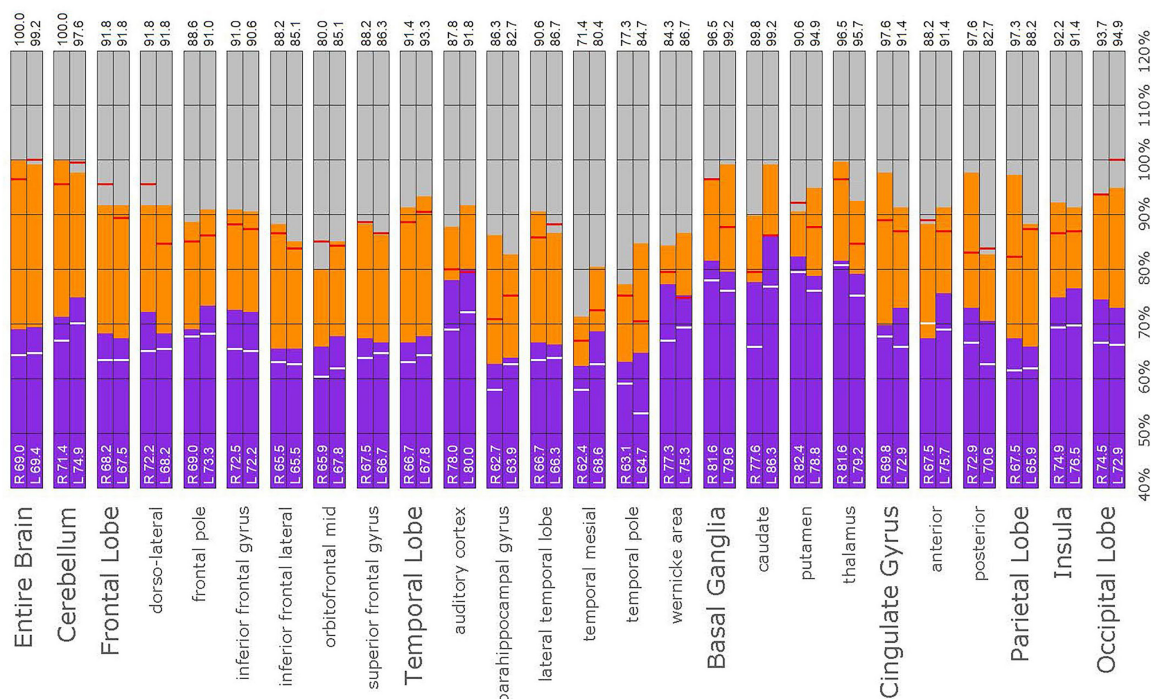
Semi-quantitative region of interest analysis of the SPECT scan of Patient B. Data analysis and presentation is as described in Figure 10. Perfusion of the thalamus is increased and asymmetrical, although not as obviously as upon inspection of the scan. Perfusion is markedly increased in the left caudate, approaching the maximal count of the cerebellum. Multiple cortical areas of increased perfusion are evident, predominately in the frontal cortices. In many ROIs, the patient's maximal counts exceed that of the normative sample, though not to the degree seen in the other cases. Portions of the frontal cortex, the lateral temporal lobe, cingulate gyri, the putamen, and the occipital lobe, which show maximal counts less than that of the normative sample, are the exceptions. In all ROIs, the patient's maximal counts exceed that of the normative sample (red line). In all ROI, the patient's median counts exceed that of the normative sample, with the exception of the right anterior cingulate gyrus (white line).
